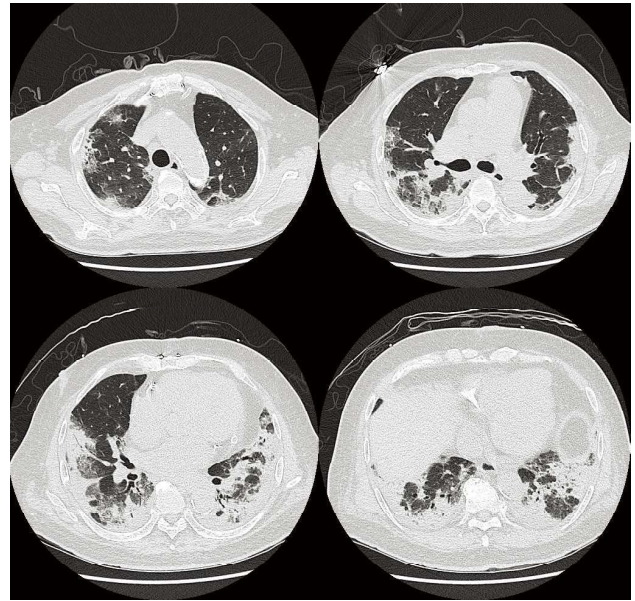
Day 8 CT shows progression of bilateral consolidation.
